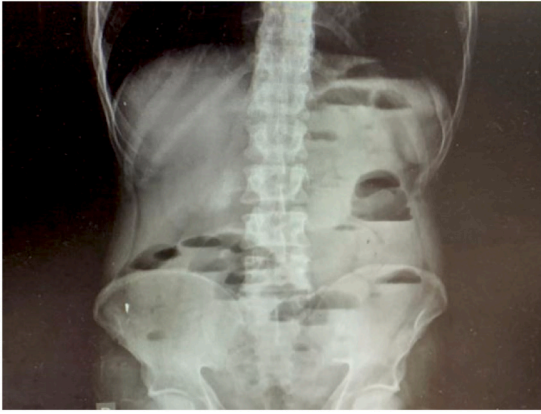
Up-right abdominal X-ray revealing air-fluid level.
